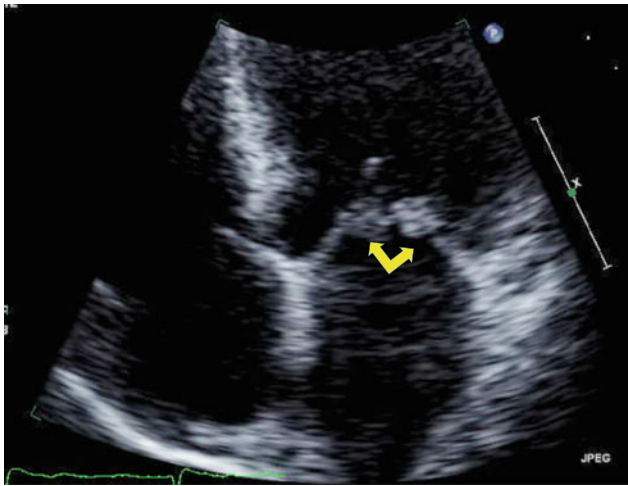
Transthoracic echocardiogram shows thickening of mitral leaflet tips (arrows)
